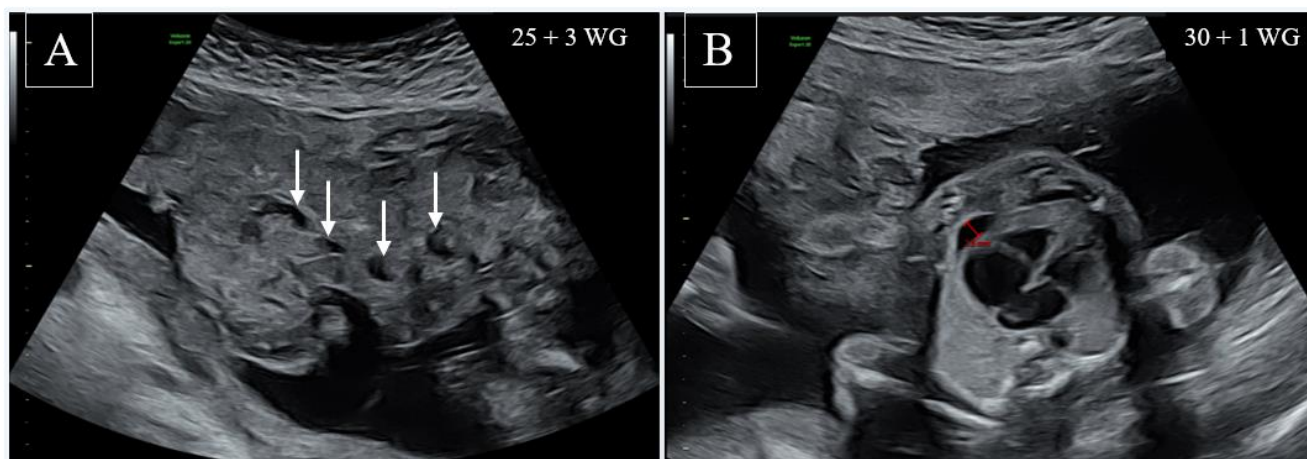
Prenatal ultrasound findings. (A) Two-dimensional ultrasound showing heterogeneous placental parenchyma with multiple cystic hypoechoic lesions (white arrows) at 25+3 weeks of gestation. (B) Axial fetal thoracic view demonstrating cardiomegaly with minimal pericardial effusion, measured at 3.8 mm (red calipers), at 30+1 weeks of gestation.
